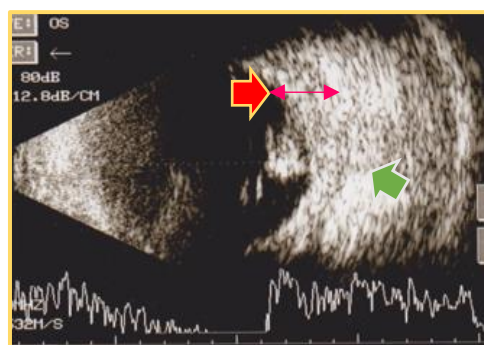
Ocular ultrasound showed retinal step sign (red arrows), elevated edematous retina, and obscured optic nerve (green arrow)
